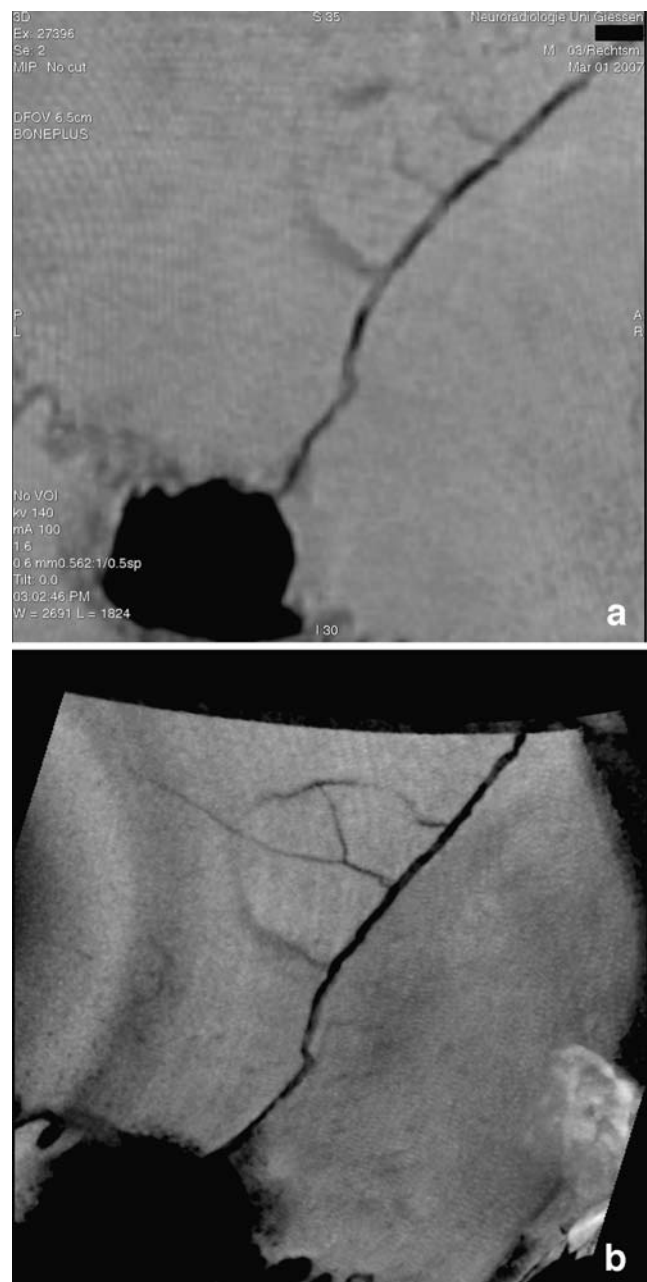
a, b Maximal intensity projection (MIP) of the MSCT data sets (a) and of the eLU-CT data sets (b). A further injury that occurred after the fracture is visible in both; it is better demonstrated in b. This most probably developed as a result of sharply localized trauma
